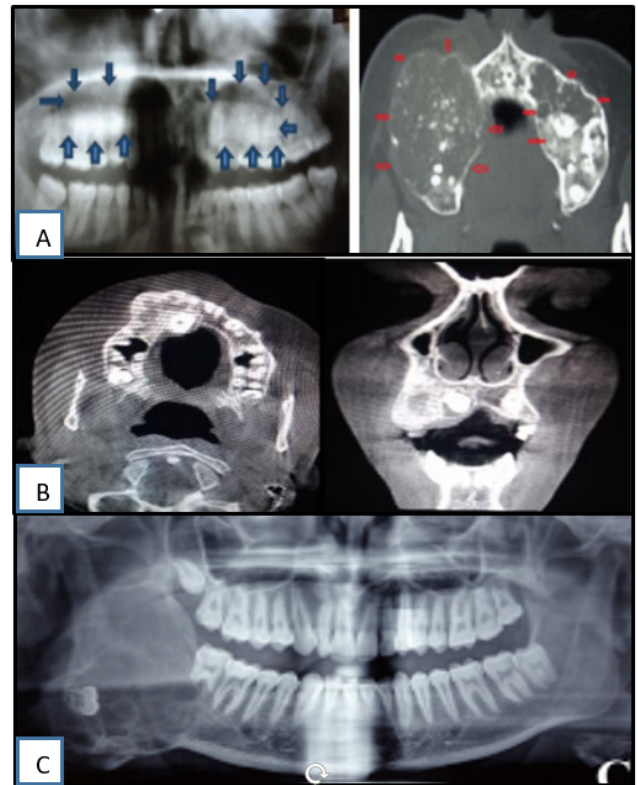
Variation in radiographic finding of Ossifying Fibroma A): Bilateral Mixed radiopacity in maxillary region. B): Expanded and thin cortical outlines with easy separation from adjacent cortical bone. D): Multilocular radiolucency involving left ramus with distal root resorption 47
